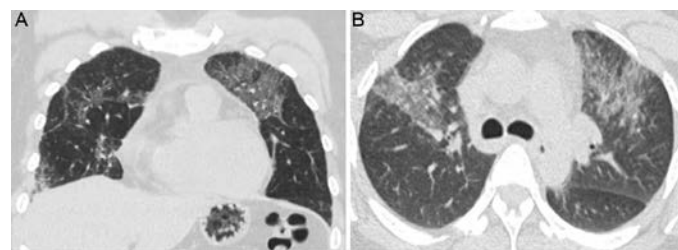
High resolution lung CT imaging of the patient on initial presentation to clinic. A. Sagittal reconstruction imaging showed upper lobe dominant ground glass opacities with diffuse fibrosis. Mediastinal lymphadenopathy was not observed. B. Expiratory axial imaging did not reveal diffuse air trapping.
